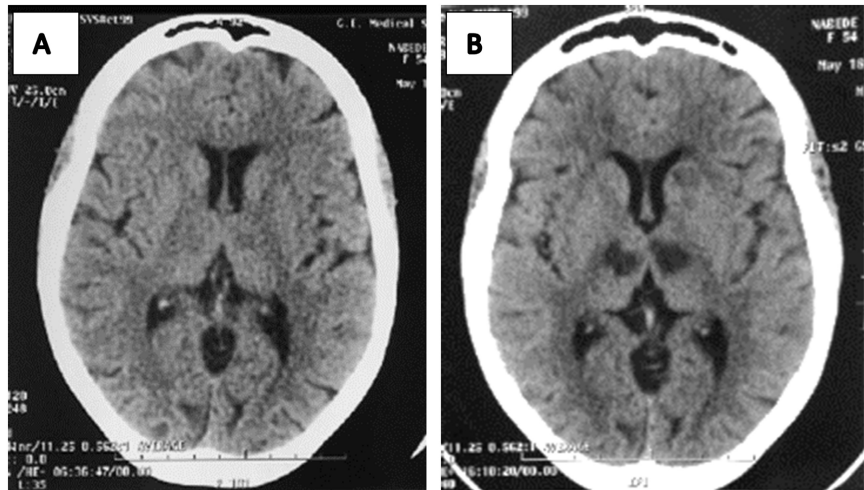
Brain CT normal at 2 hours (A), then at 48 hours showing anterior and paramedian bithalamic hypodensities (B).
